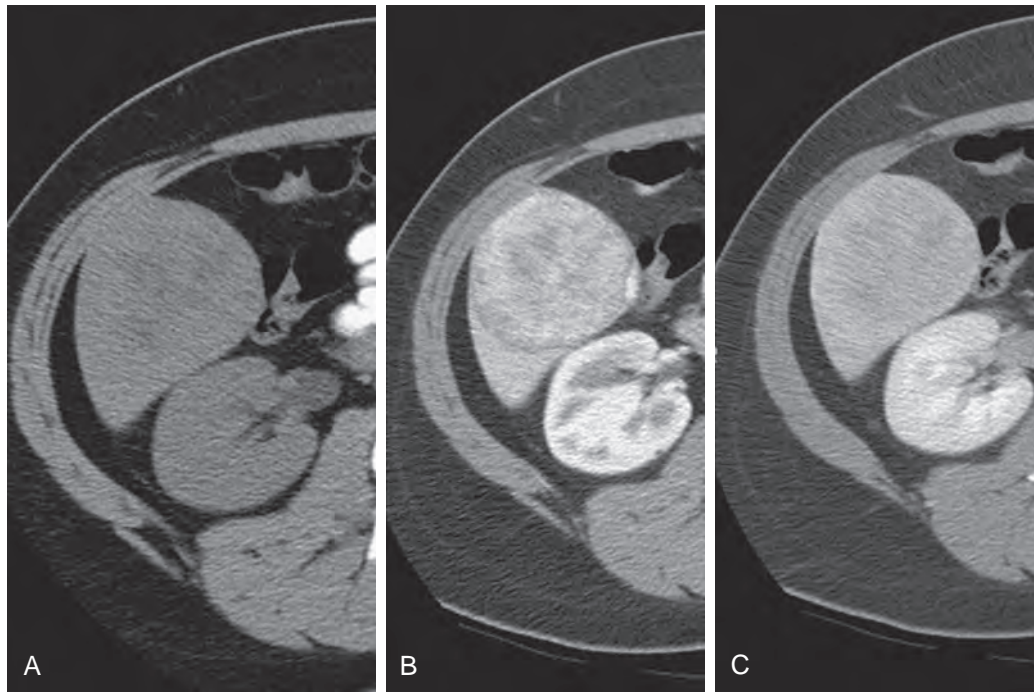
Adenoma: CT features. A. Noncontrast scan shows an inhomogeneous mass with areas of low density. B and C. A mosaic, inhomogeneous enhancement pattern is seen after intravenous administration of contrast material.
